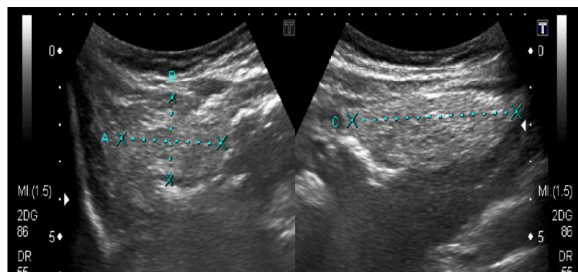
Longitudinal & transverse ultrasound images from right iliac fossa showing echogenic localized fat in right iliac fossa.
